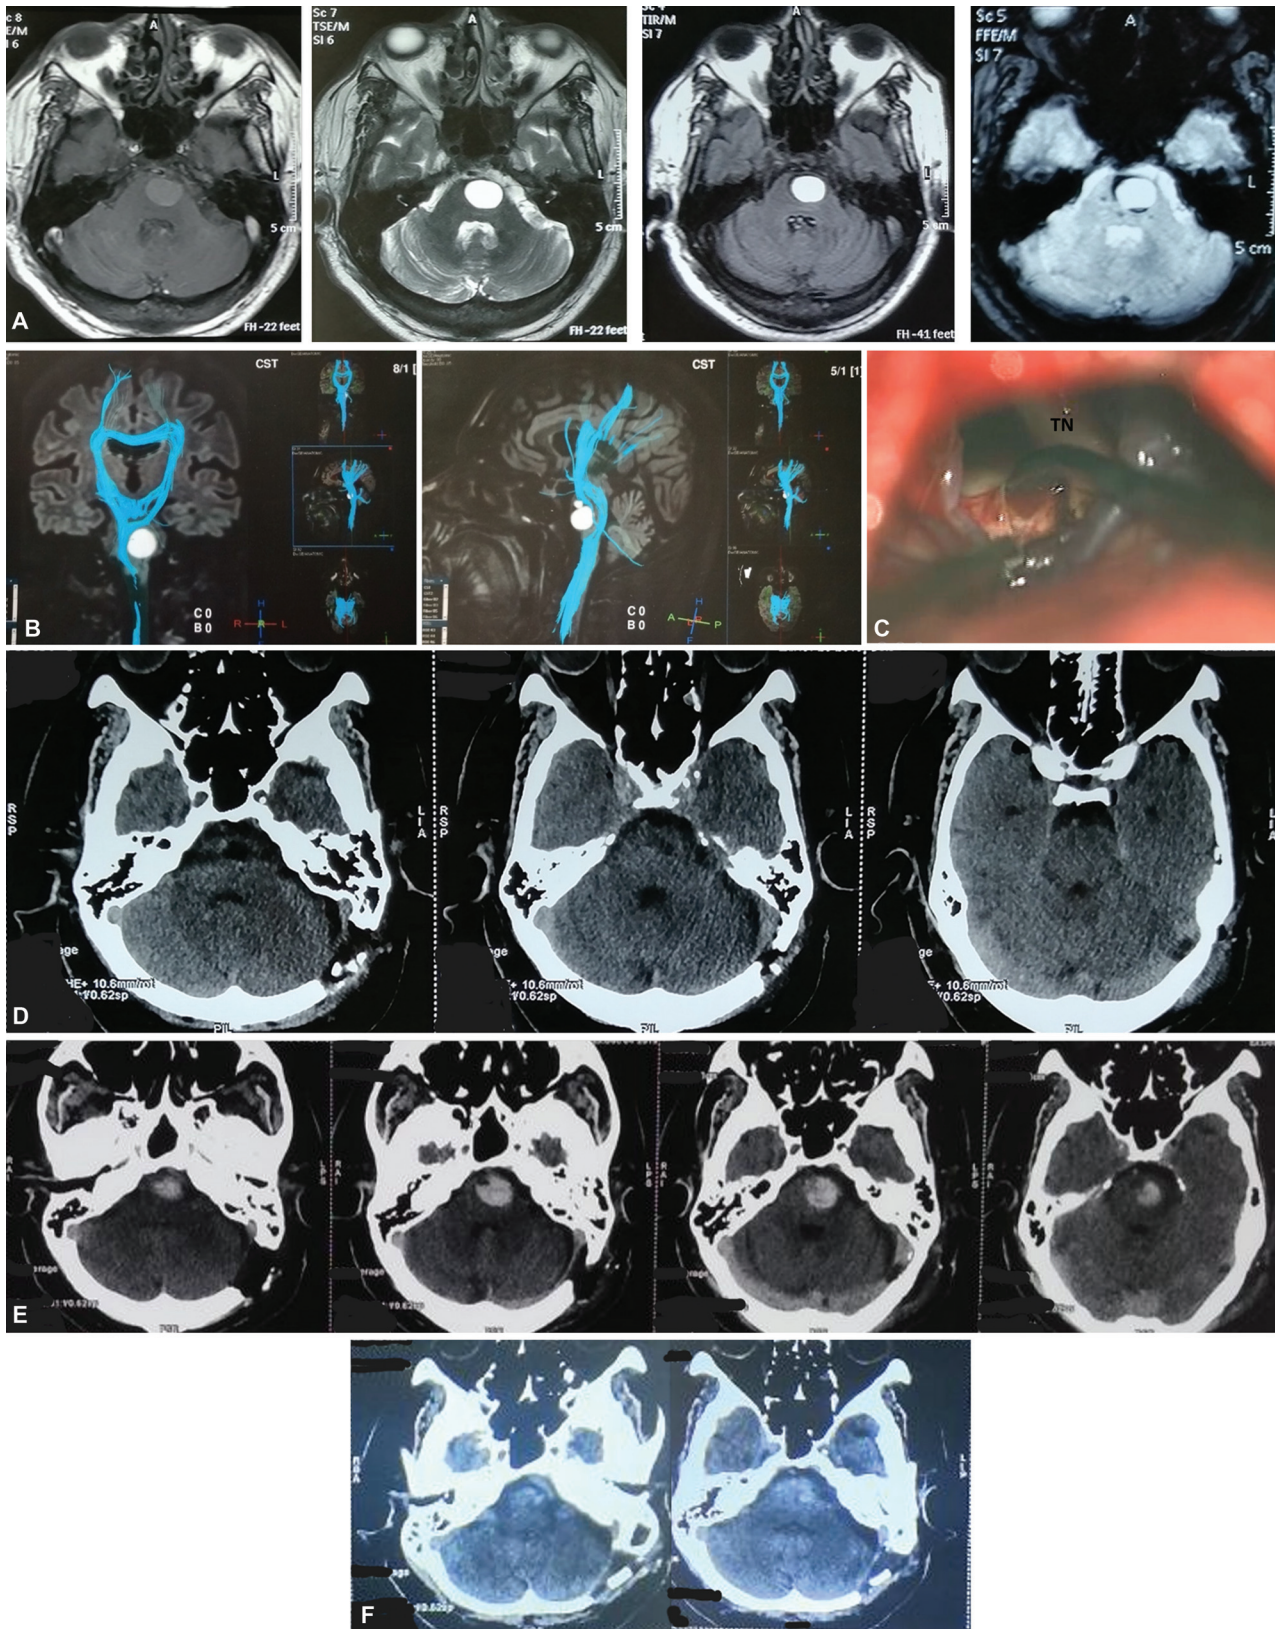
(A) (Left to right) T1-weighted (T1W), T2W, fluid-attenuated inversion recovery and gradient echo (GRE) images of a 61-year-old gentleman with a purely cystic pontine lesion. GRE shows a fluid level within and a peripheral hypointense rim of hemosiderin suggestive of a cavernoma. (B) Diffusion tensor images (tractography) showing that the corticospinal tract was displaced to the right and behind the lesion. (C) Intraoperative photograph showing the incision in the pons in the peritrigeminal zone (near the root entry zone of the trigeminal nerve [TN]) and drainage of xanthochromic cystic fluid followed by excision of the rim. (D) Immediate postoperative computed tomography (CT) scan showing gross total excision. (E) CT scan done on the fifth postoperative day which showed a hematoma at the site of the cyst. (F) CT scan after second surgery for evacuation of hematoma and excision of residual capsule.
